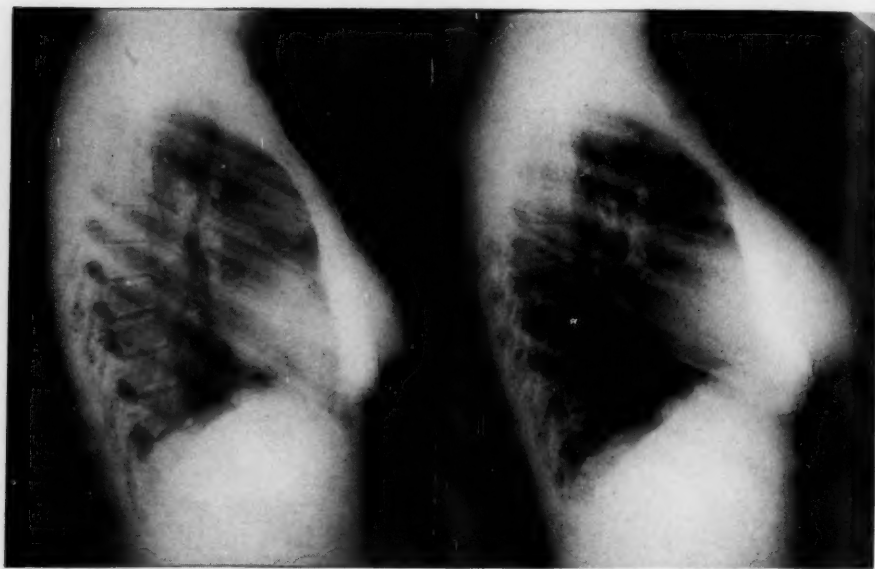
Preoperative, lateral roentgenogram of chest showing tumor in anterior mediastinum.
